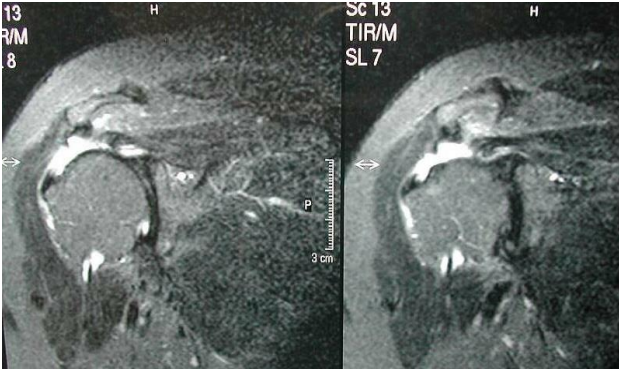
Pre-operative pictures of the MRI of the same patient showing a large rotator cuff tear in the supraspinatus muscle.
